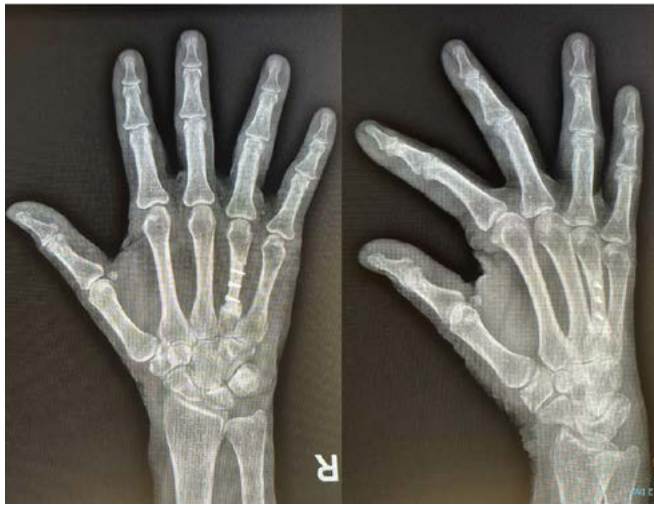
Anteroposterior and oblique x-ray views 4 months after metacarpal step-cut osteotomy and fixation with lag screws.
